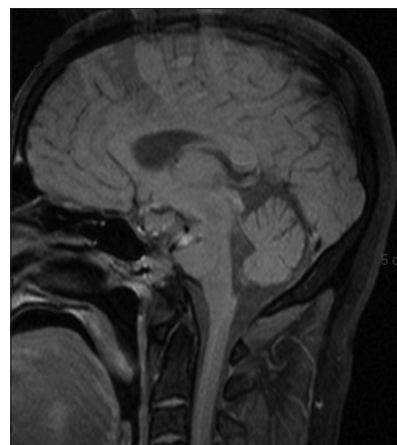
Sagittal MRI T1 imaging showing residual fat and no signs of tumor recurrence
